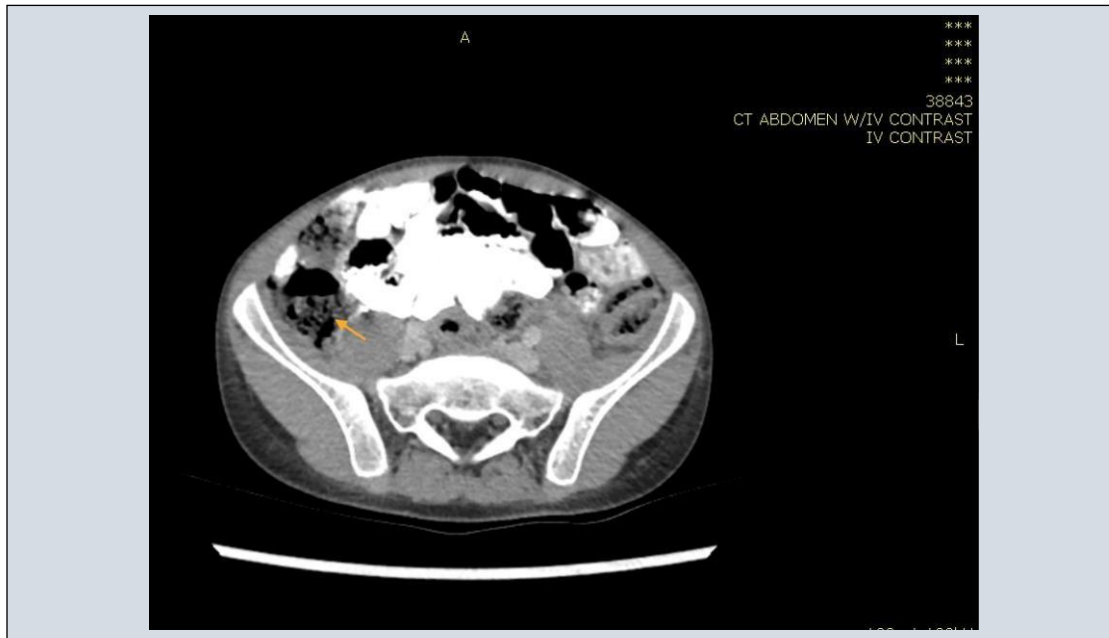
CT scan of the abdomen with iv contrast revealed no evident bowel wall thickening (orange arrow). The liver is average in size, showing well defined marginally calcified lesion about 1.8 cm in the posterior segment of the right lobe, consistent with calcified granuloma, impressive of healing of the previously noted hepatic abscesses (yellow arrow). No further hepatic lesions. Patient was put on regular follow up both radiological and clinical every 3 months with no relapsing feature
